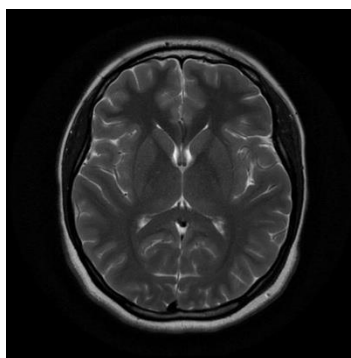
MRI Brain Showing No Obvious Abnormality
